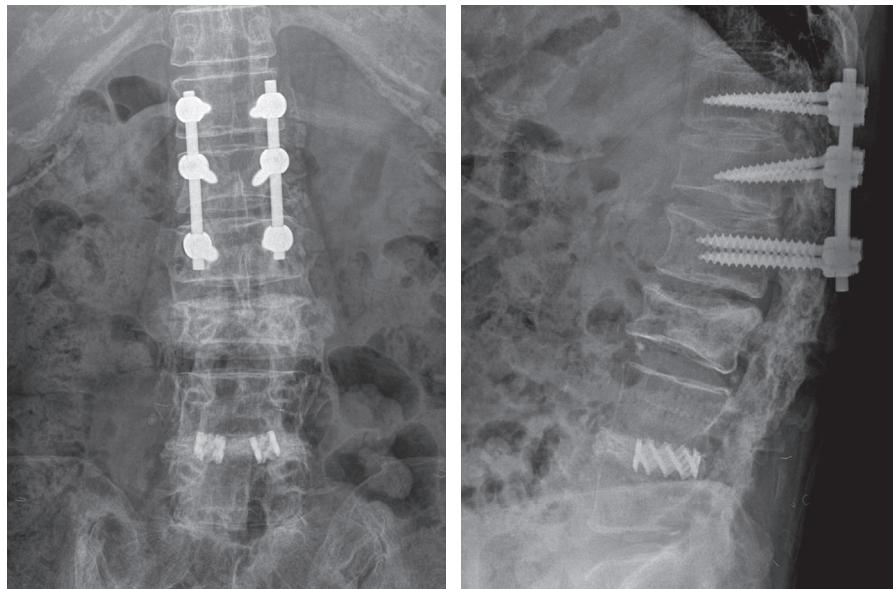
(Left) Lumbar anteroposterior and (Right) lateral radiographs at 3 months after surgery. The collapse of the L3 body had progressed.
